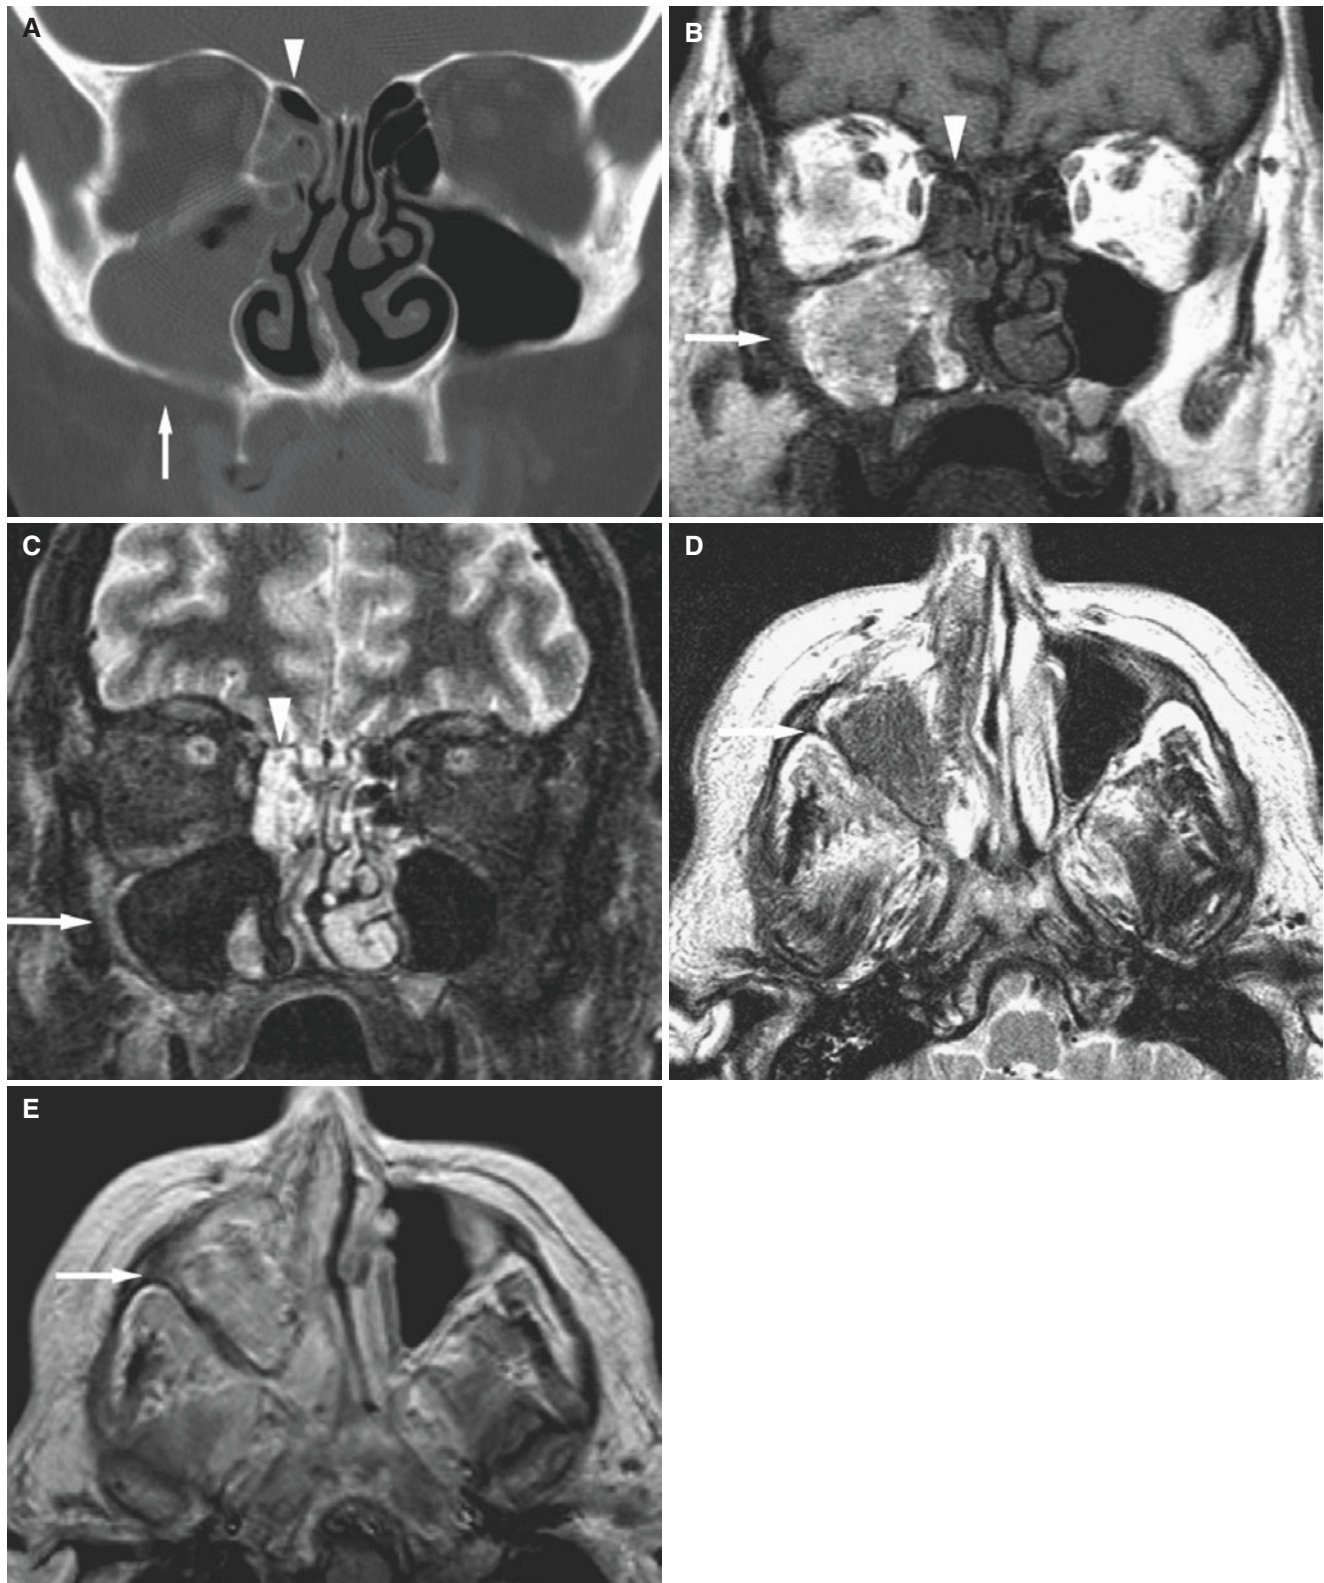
Chronic *Aspergillus* sinusitis; 57-year-old female with history of acute lymphatic leukemia, neutropenic status post chemotherapy, now with eye and cheek pain. (A) Coronal CT image shows opacification of right maxillary sinus (*arrow*) and ethmoid sinus (*arrowhead*). (B) Coronal T1-weighted MRI shows intermediate to high signal in maxillary sinus (*arrow*) and low signal in ethmoid sinus
